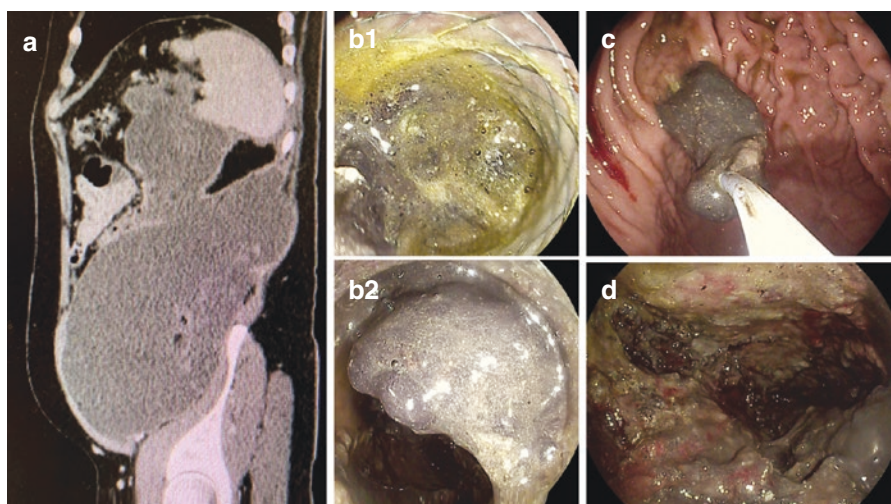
Endoscopic necrosectomy of an infected walled-off pancreatic necrosis (WOPN). (a) CT view of a large WOPN. (b1) Infected necrosis obstructs the biflanged fully covered metal stent (placed through the gastric wall under EUS guidance). (b2) Infected necrotic tissue inside the neocavity. (c) Necrosectomy performed using a polypectomy snare with necrotic tissue inside the gastric cavity. (d) The neocavity after partial necrosectomy
